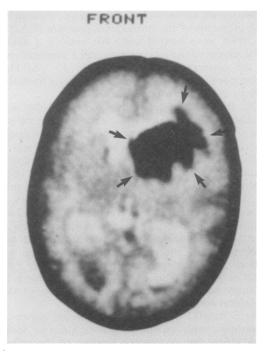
Computed tomogram one day before surgery. Blood clot is situated in right anterior horn and periventricular white matter (indicated by arrows).
